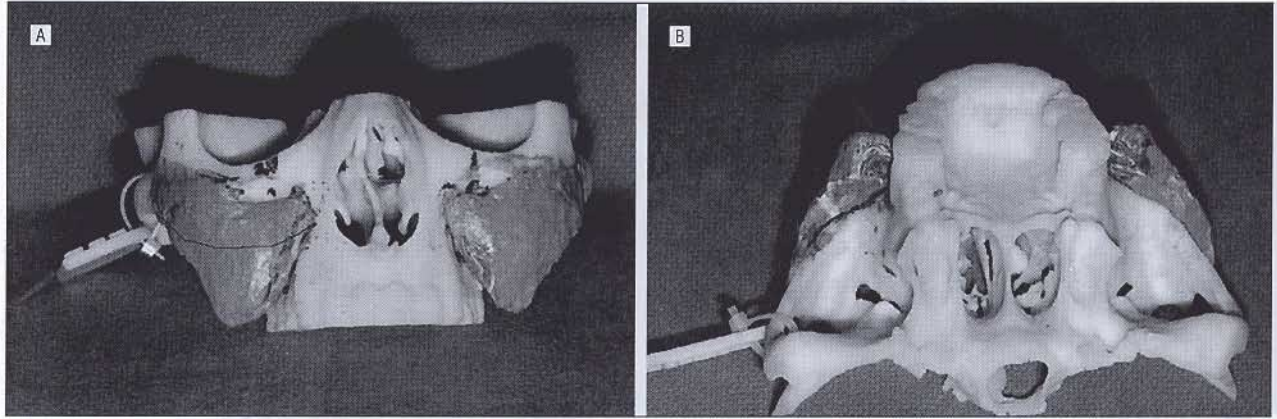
High-resolution computed tomographic 3-dimensional computer-aided design and computer-aided manufacture (CAD/CAM) model demonstrating the fabrication of custom-designed silicone midfacial implants that are used to correct the characteristic appearance of facial wasting syndrome. A, The line on the right side of the model indicates the inferior border of the maxillary bone. B, Note the thickness of the implant (9 mm).
